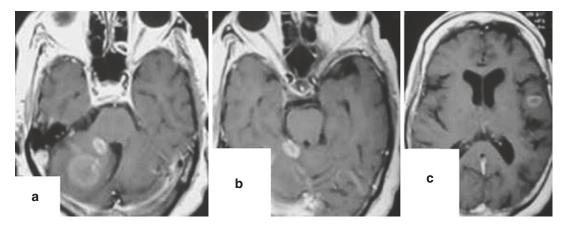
(a–c) Contrast MRI of the brain in axial sections showing tuberculomas in the right side of the cerebellum, right superior and middle cerebellar peduncle, and left superior temporal gyrus
